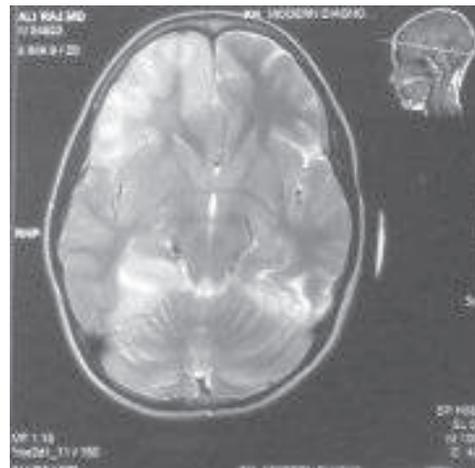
T_2 weighted MRI showing similar changes as found in TW_1 MRI
